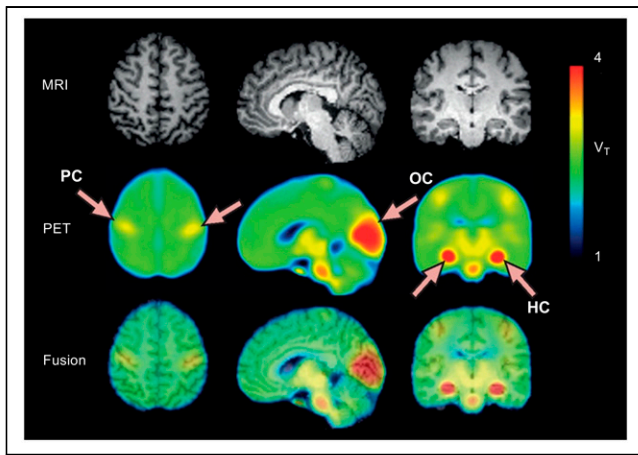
Distribution of COX-1 in healthy human brain. After ^{11}C -PS13 injection, enzyme density was calculated on the pixel level as distribution volume (V_T). The MRI is from a representative participant, and PET images of COX-1 are an average from 10 participants. Notable ^{11}C -PS13 binding (arrows) was detected in hippocampus (HC), occipital cortex (OC), and pericentral cortex (PC). The third row shows images fused from MRI and PET scans. (Reprinted from (19).)
